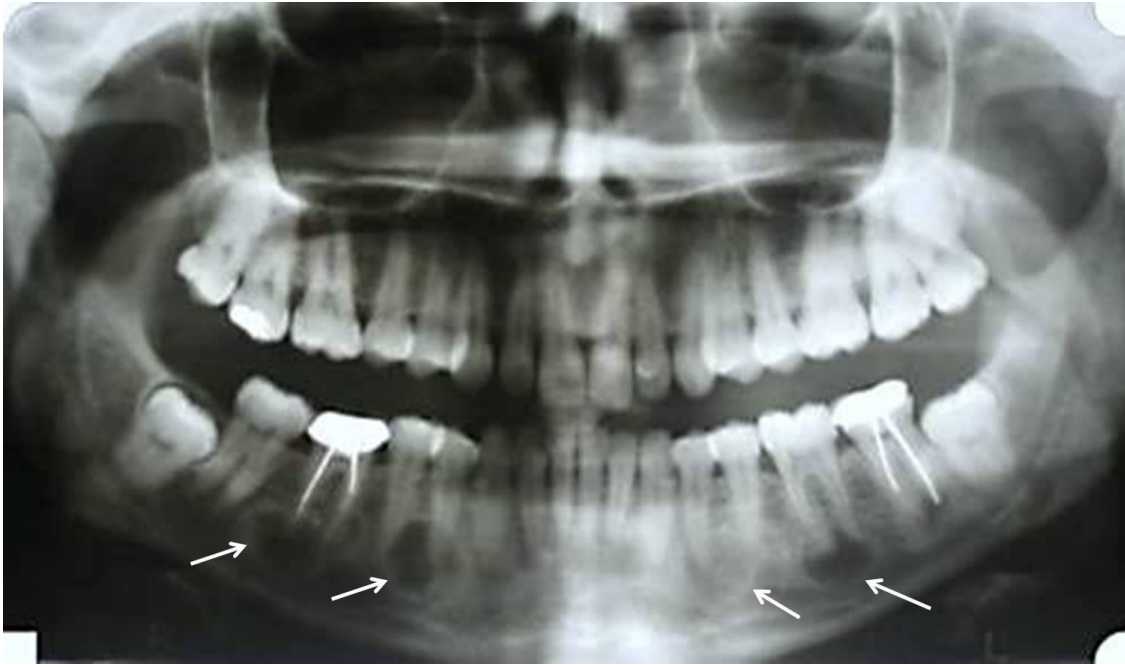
Orthopantomograph showing bilaterally symmetrical, well-defined lesions of variable radiodensities in the apical region of mandibular posterior teeth.
